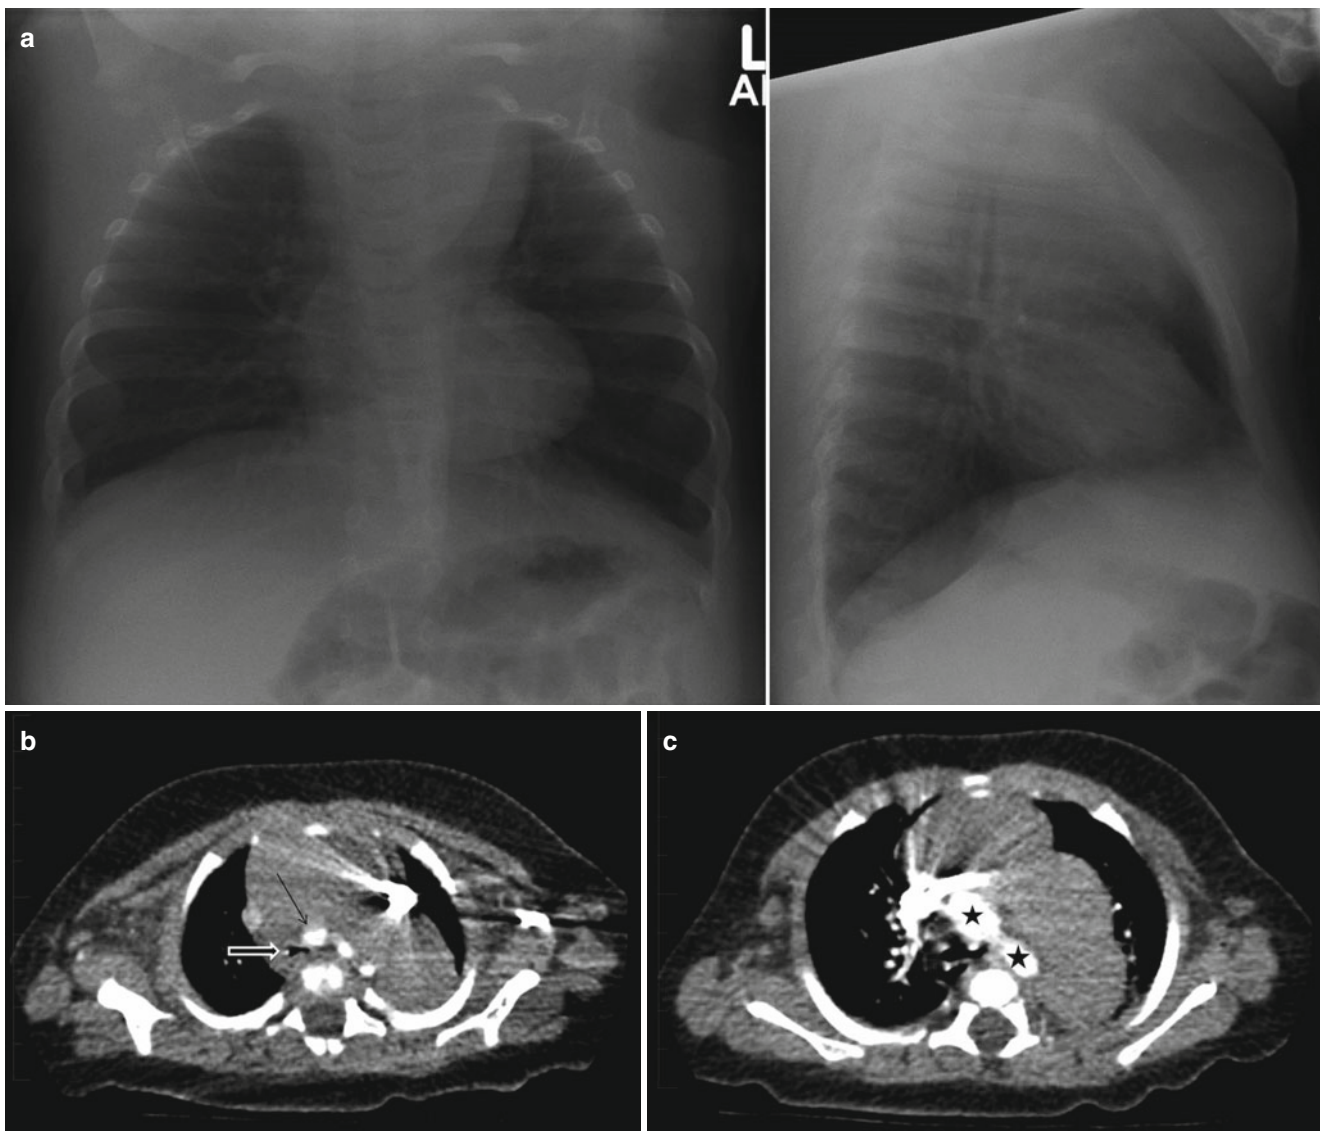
A 4 month old girl presented with stridor and wheezing. (a) The chest radiograph showed an anterior mediastinal mass. (b) CT scan showed marked compression of the trachea (*thick arrow*) at the level of the brachiocephalic artery (*thin arrow*); artefacts are due to contrast injection in the left arm. (c) The mass extended posteriorly, and inferiorly
